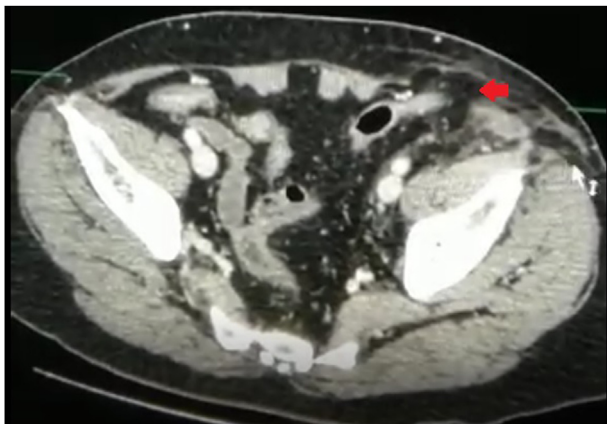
CT axial view showing left iliac fossa traumatic hernia.
